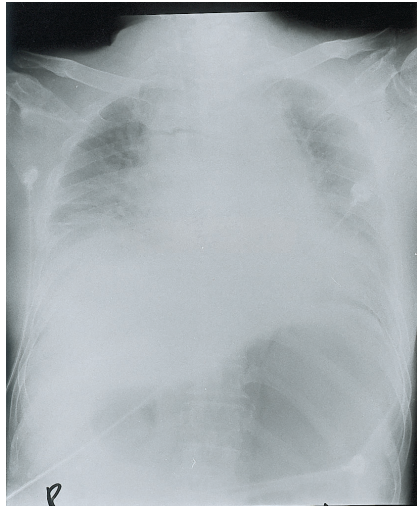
Chest X-ray (anteroposterior view) shows bilateral pleural effusions with cardiomegaly and mediastinal widening.
